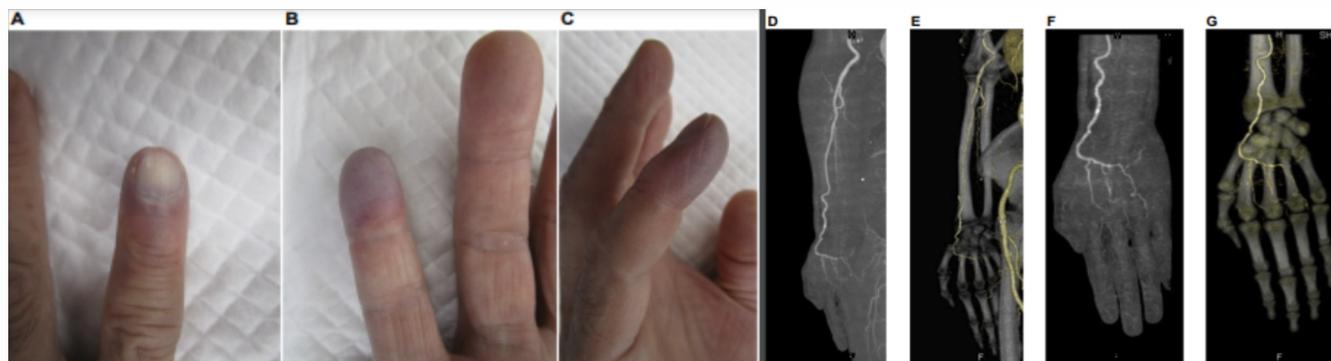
Physical and radiological findings of the patient. (a-c) The ischemic change in the skin was distal to the DIP joint of the little finger of the right hand. (d and e) Enhanced CT showed that the ulnar artery was occluded at the bifurcation from the brachial artery. (f and g) Enhanced CT showed a superficial palmar arch from the radial and palmar metacarpal arteries. The radial digital artery of the little finger was interrupted at the MP joint. CT: Computed tomography, DIP: Distal interphalangeal, and MP: Metacarpophalangeal.
